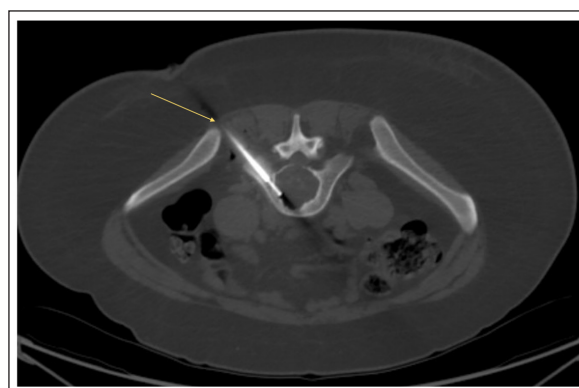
CT-guided biopsy approach from L5 vertebral body lesion (Yellow arrow).
